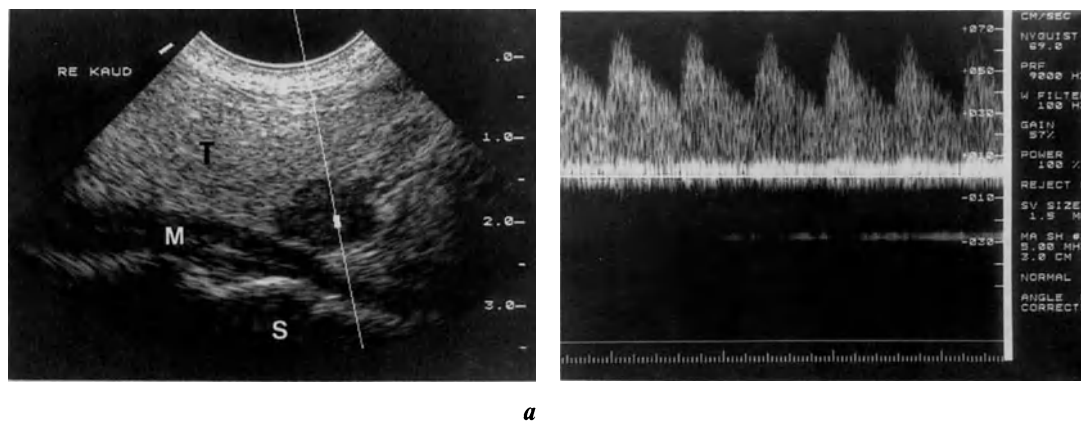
a, b*. Typical appearance of parathyroid adenoma in a patient with primary hyperparathyroidism. There is a hypoechoic nodule in the parathyroid region, in which arterial Doppler signals with high diastolic flow velocity can be recorded. (T = thyroid gland, M = longus colli muscle, S = cervical spine)
